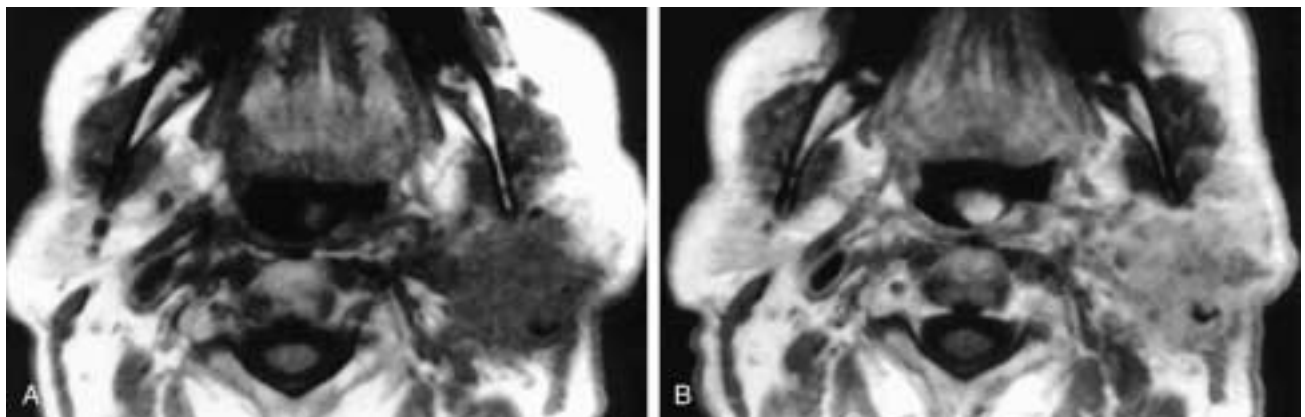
Axial T1-weighted (A) and T1-weighted, contrast-enhanced (B) MR images show a poorly defined infiltrating mass in the left parotid gland that has irregular enhancement. The tumor had low signal intensity on T2-weighted images. This patient had an adenocarcinoma.
